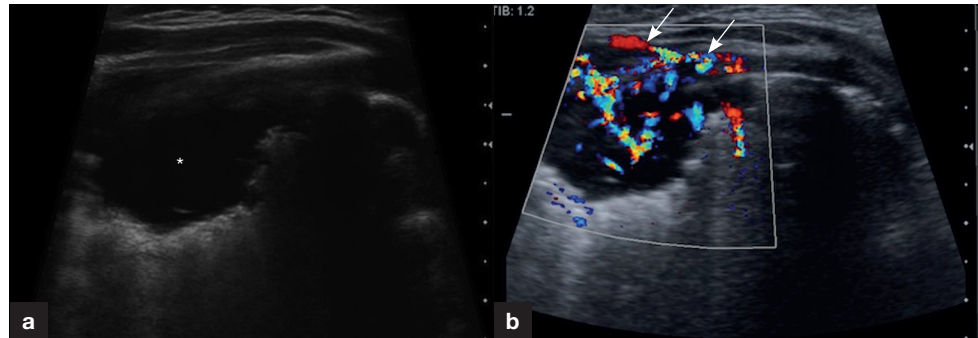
a. B mode and (b) colour Doppler images of lung consolidation (asterisk) located in the right upper lobe revealing extension beyond lungs through chest wall (arrows).
